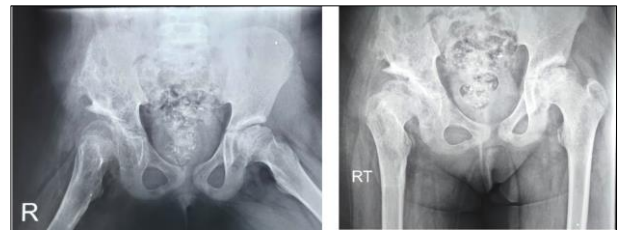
Follow up x-ray 9 months postoperatively show healed RT sided shelf osteotomy
